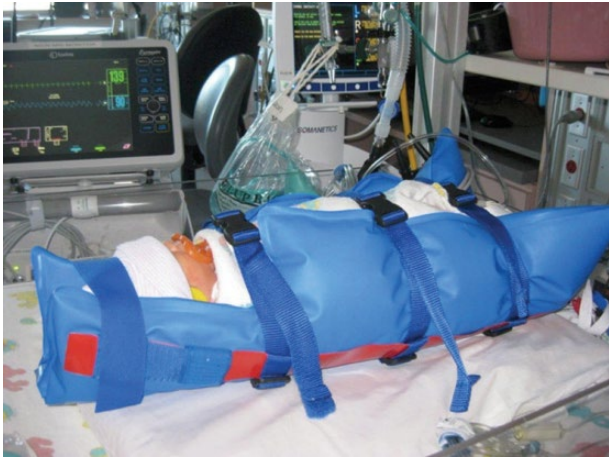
Feed and swaddle technique for non-sedated MRI in young infants. The neonate is wrapped in blankets and a vacuum bean bag, with noise attenuators in place, ready for transport to the MRI scanner suite. Source: Reproduced from Barkovich et al [291] with permission of Springer Nature.
